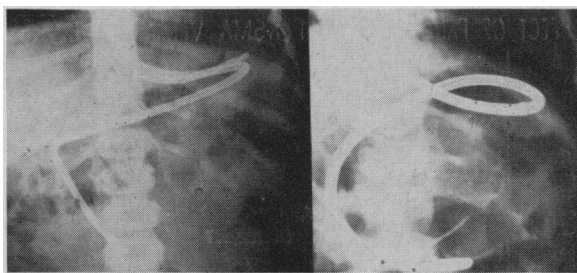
(A) X-ray showing two separate single-lumen tubes in place for separate drainage of gastric and duodenal fluids in a three-year-old child. (B) X-ray showing a bi-lumen tube in a 10-month-old infant. The duodenal tubes in the two films are of the same outside diameter (12 French).
